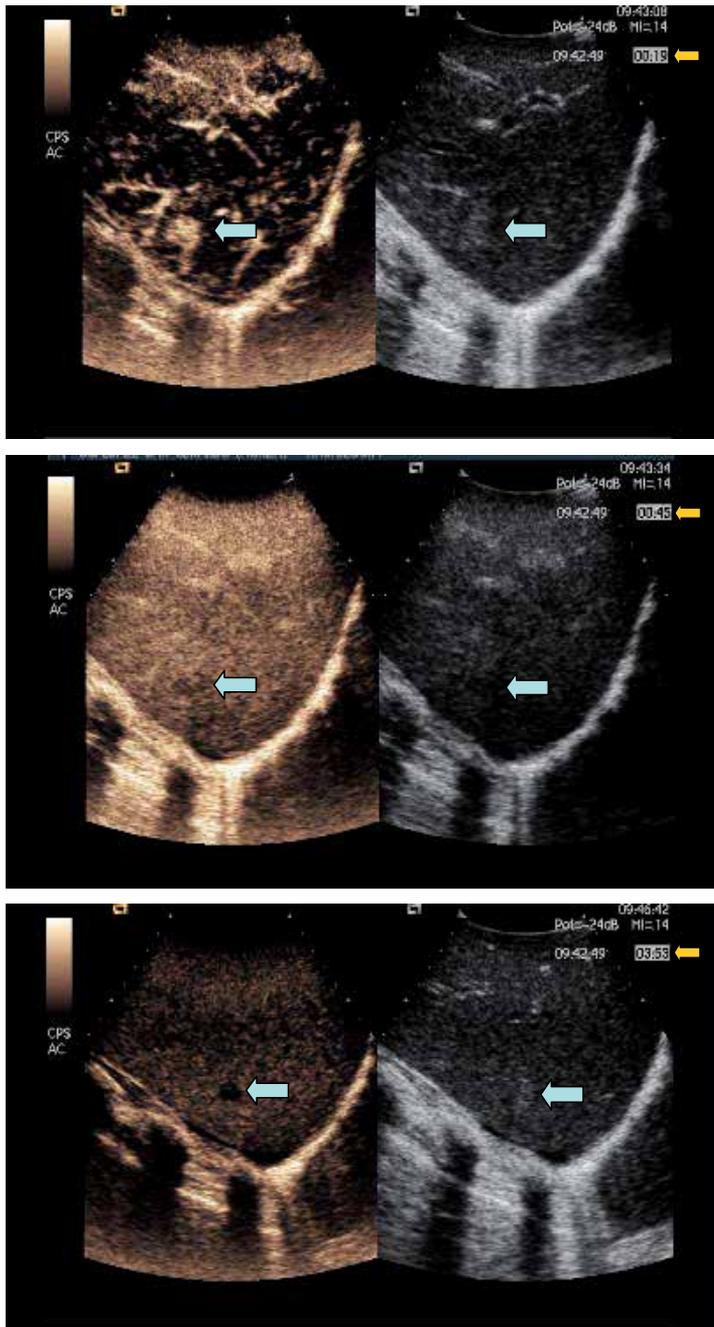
This picture shows a colorectal liver metastases (indicated by azure-blu arrows) in the arterial, portal and tardive phases (time passes form the injection of contrast agents is indicated by yellow arrows) during an contrast-enhanced intra-operative ultrasound study.
